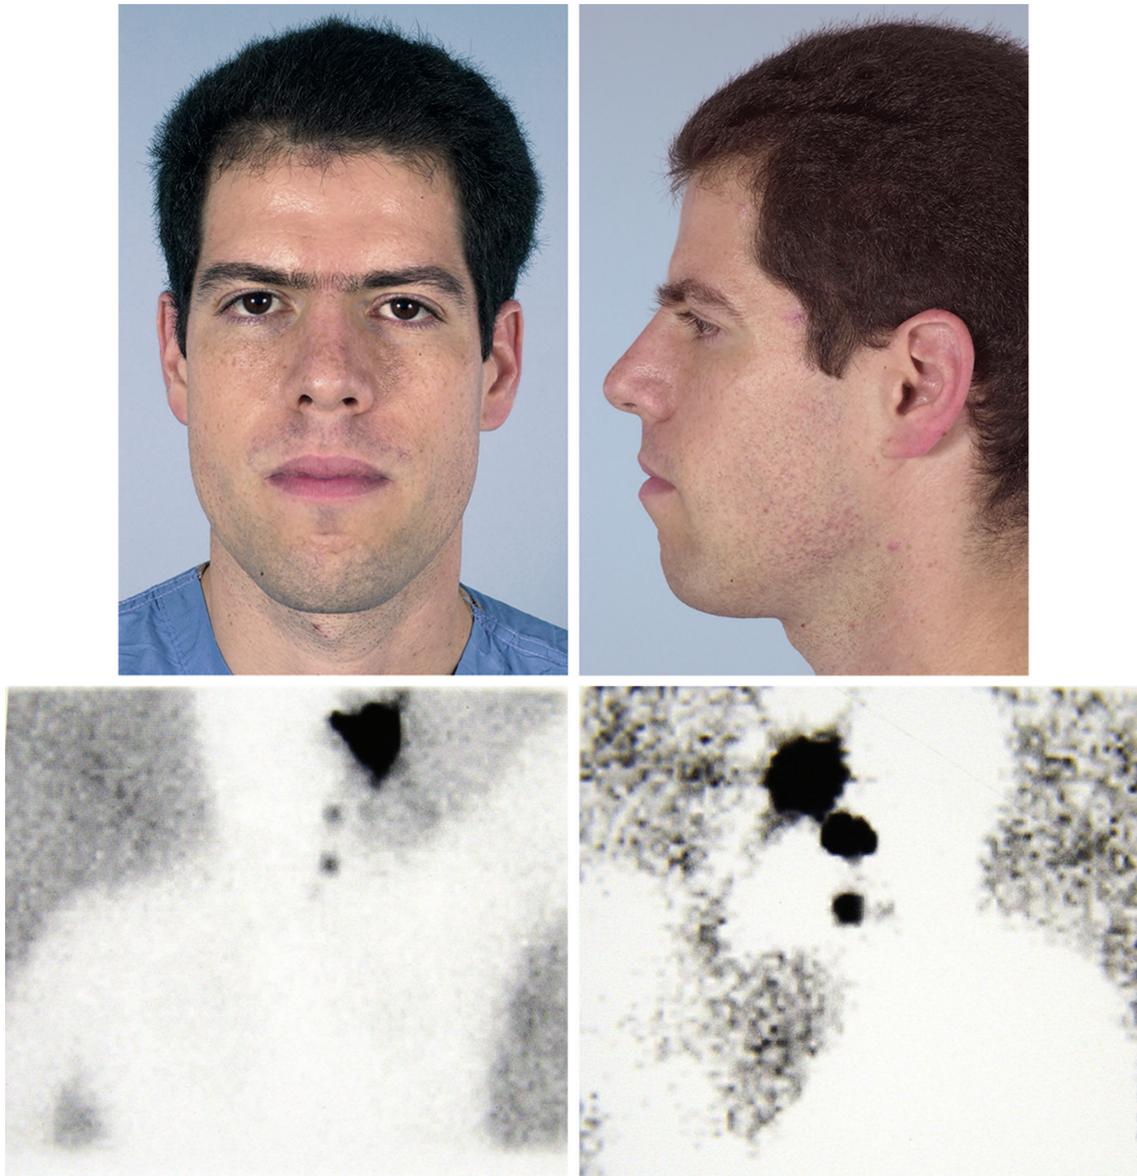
(Above) Preoperative photographs of a 31-year-old man with a superficial spreading melanoma located on his left temple. Biopsy revealed a Breslow depth of 1.4 mm. (Below) Lymphoscintigraphy demonstrates drainage to the parotid nodes and level II nodal basin.
